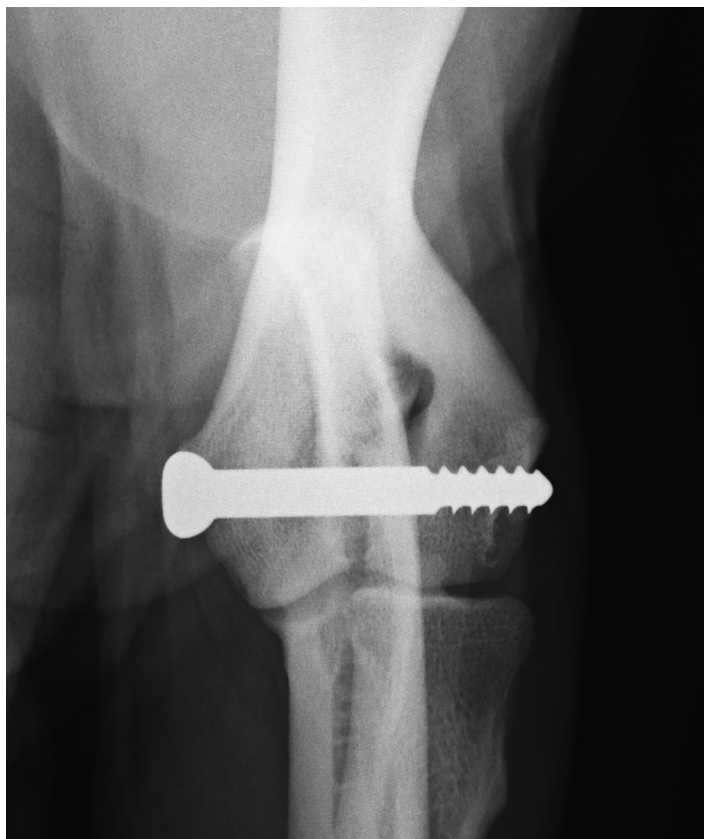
Postoperative radiograph of a transcondylar 4.5-mm shaft screw, placed in a 2-year-old English Springer Spaniel.
